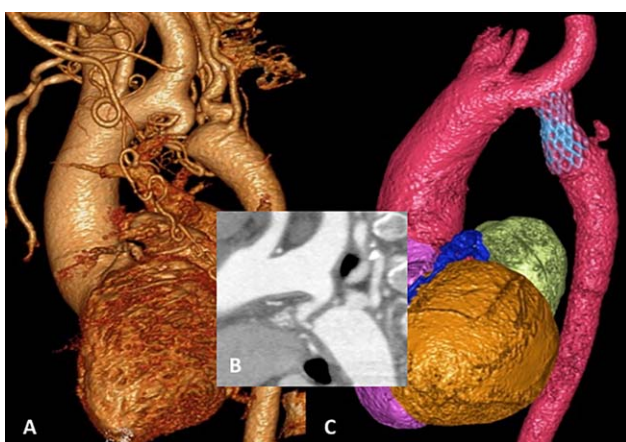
Severe, near atretic native coarctation in a young adult patient successfully treated with the Optimus stent. Panel A (3D reconstruction from CT imaging) and B demonstrate a severe tortuous long segment narrowing with isthmal hypoplasia and significant collateral vessel development. Panel C shows the result after inflation of the Optimus stent without high pressure redilation
